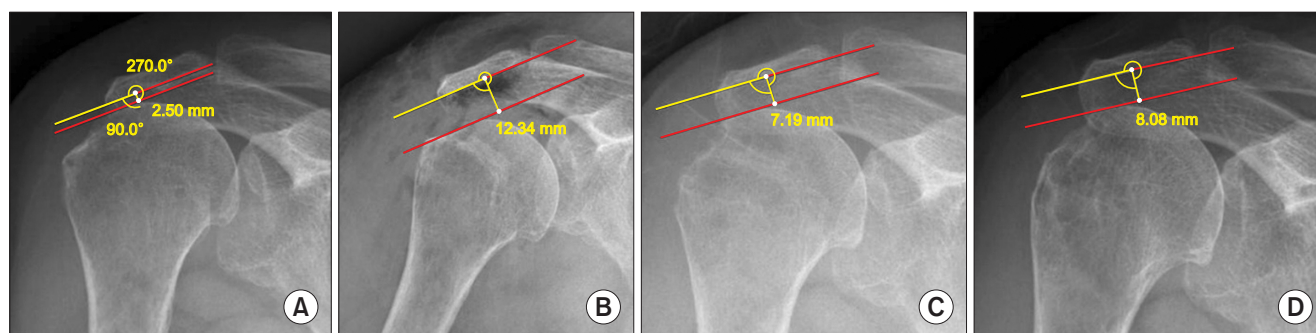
Simple right shoulder anteroposterior X-ray of a 73-year-old female. Acromiohumeral distance (AHD) was measured as the distance between the inferior aspect of the acromion and the subchondral lamina of the humeral head. (A) Preoperative AHD (2.50 mm). (B) Postoperative AHD (12.34 mm). (C) Six months postoperative AHD (7.19 mm). (D) Seventeen months postoperative AHD (8.08 mm).
